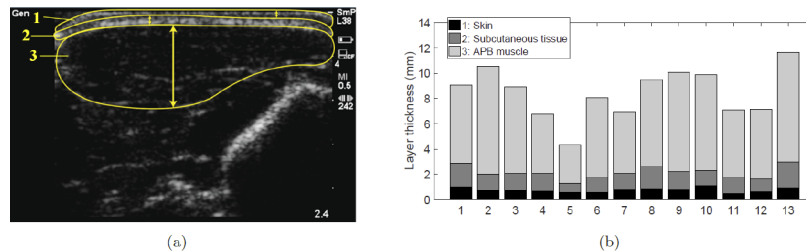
(a) An ultrasound image acquired from one subject. Three different structures can be defined: the skin (1), the adipose subcutaneous tissue (2) and the abductor pollicis brevis (APB) muscle (3). (b) The three layer thicknesses measured in all the subjects. The skin and adipose subcutaneous tissues are referred as the superficial layer for the rest of the manuscript.
